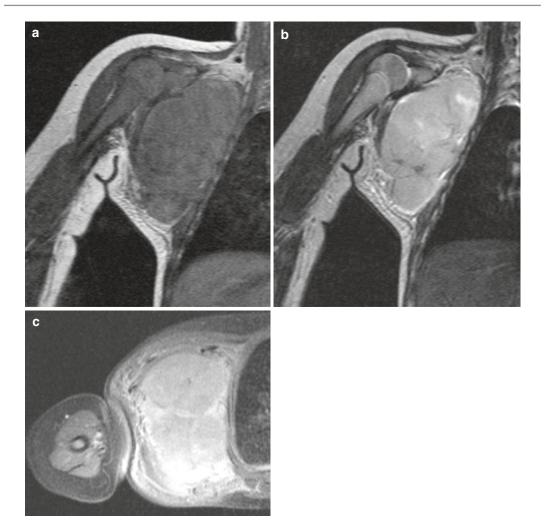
Fibrosarcoma in a 1-year-old girl. (a–b) Coronal T1- and T2-weighted MR images show a large soft tissue mass in the right axilla. (c) Axial CE FS T1-weighted image depicts intense homogeneous enhancement of the lesion
